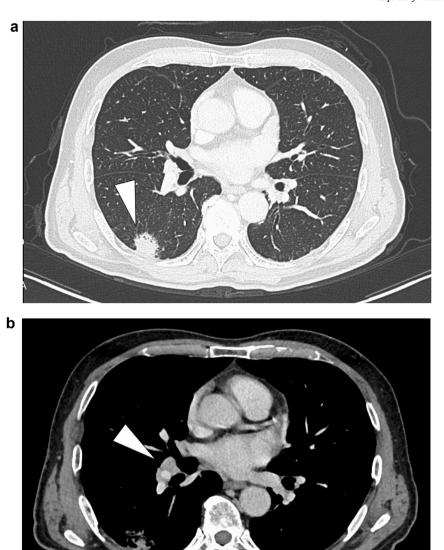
CT shows (A) a solid nodule in the right lung (white arrowhead) and (B) slight enlargement of the interlobar lymph node (white arrowhead).
